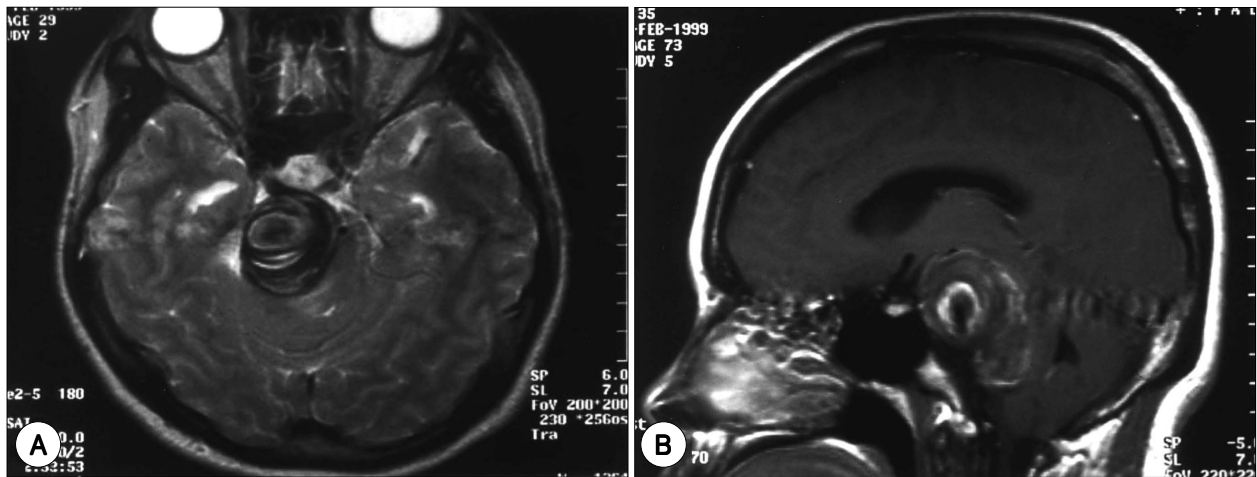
Initial magnetic resonance images. T₂-weighted axial image (A) and T₁-weighted sagittal image (B) demonstrating a lamellated mass compressing brain stem. The mass contains a acute hemorrhage, thrombus, and signal void.
